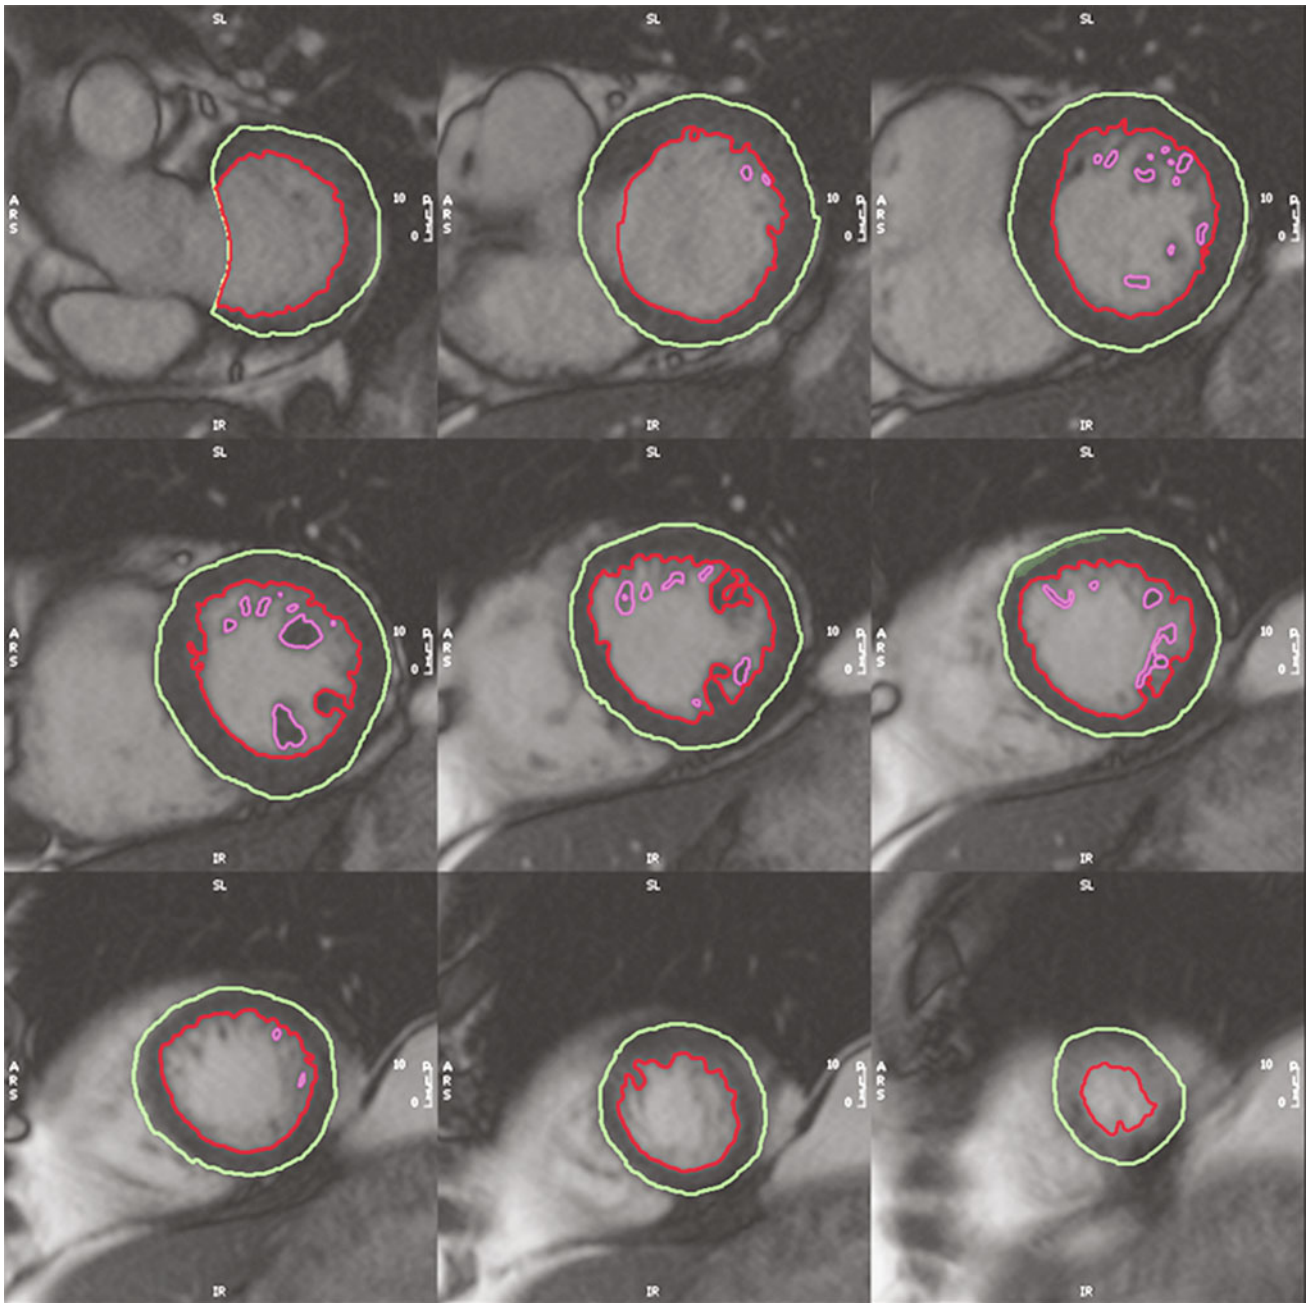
Images from a short-axis stack on cardiac magnetic resonance imaging. A short-axis stack showing slices of the heart from the atrioventricular junction (slice 1) down to the apex (slice 9). These
